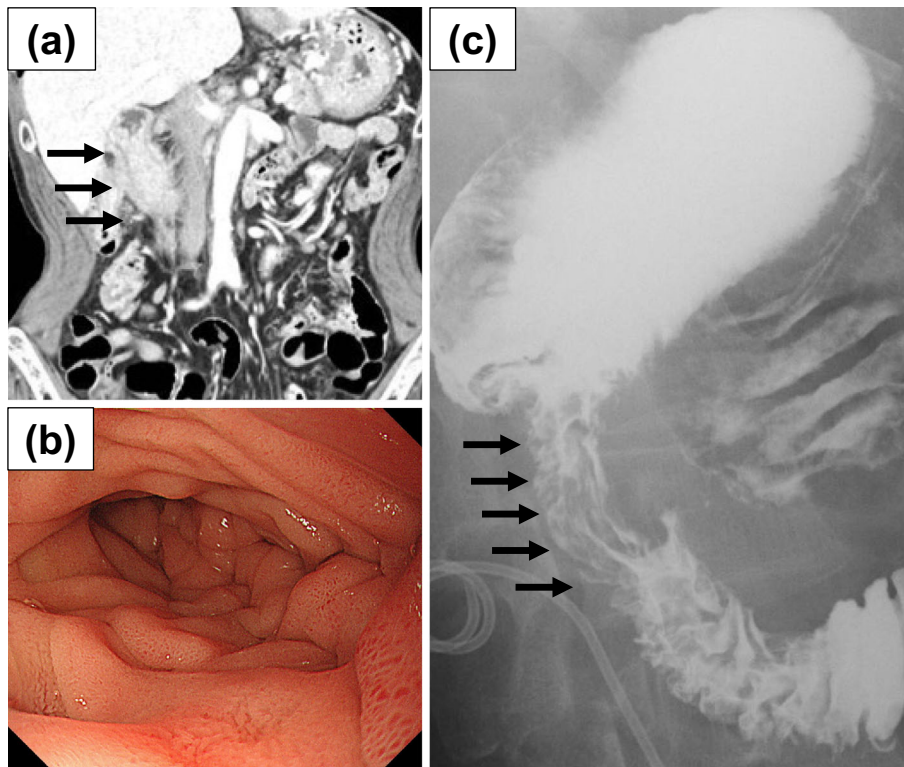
The appearance of the duodenal stenosis on the initial visit. (a) Abdominal computed tomography on the first visit showed thickening of the duodenal wall with no other specific findings. (b) Esophagogastroduodenoscopy revealed circumferential stenosis without erosion or ulceration at the descending part of the duodenum. (c) Hypotonic duodenography using barium revealed smooth stenosis in the lumen (arrows).
